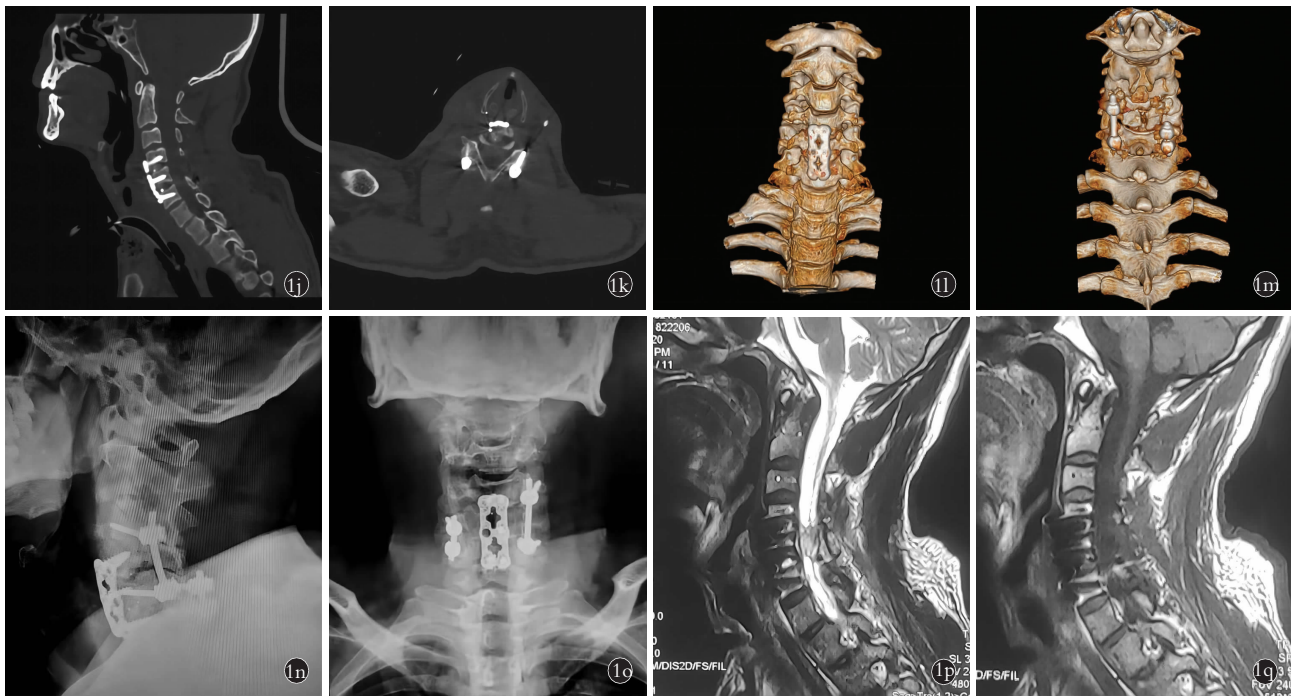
男性患者,34 岁,高空坠落致四肢瘫痪 6 h 余 lj, lk. 术后 1 周 CT 示颈椎脱位恢复,内固定位置合适 ll, lm. 术后 1 周 CT 三维重建提示颈椎序列恢复正常,复位效果良好 ln, lo. 术后 10 个月颈椎正侧位 X 线示内固定位置良好 lp, lq. 术后 10 个月 MRI 示减压充分
